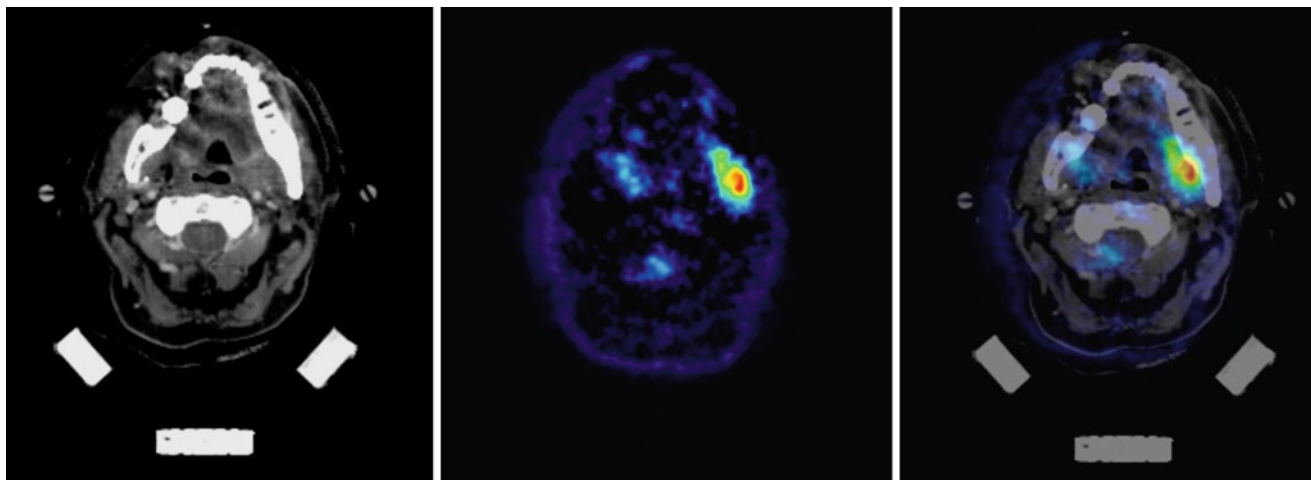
CT (left) and dPET study with FDG (middle) of a patient with a recurrent squamous cell carcinoma. Parametric images of the FDG metabolic rate were calculated from the dPET data and fused with CT (right)
